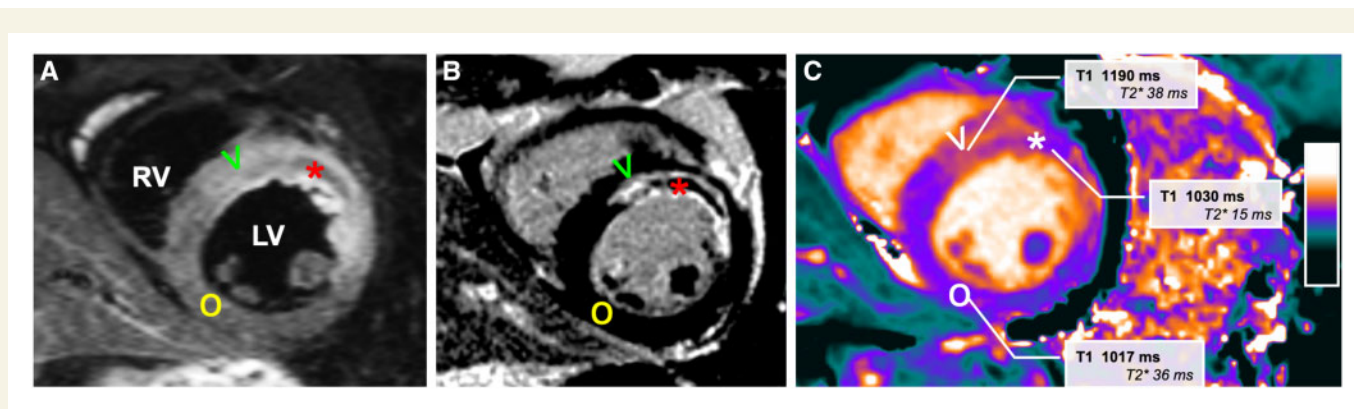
CMR images of a patient after acute anterior myocardial infarction. Typical example of a patient after acute anterior myocardial infarction with microvascular injury, demonstrating hyperintense oedematous myocardium on the T2-weighted image (A, V) compared to remote non-infarcted myocardium (O), with the corresponding delayed contrast-enhanced image showing the infarcted hyperenhanced infarcted myocardium (B, V) with a hypointense infarct core (asterisk) with microvascular injury. The area with microvascular injury has low T1 on the non-contrast T1 map (C, asterisk) and low T2*, whereas the area of infarction has increased T1 relaxation times and normal T2* decay times, not containing haemoglobin breakdown products. LV, left ventricle; RV, right ventricle.
